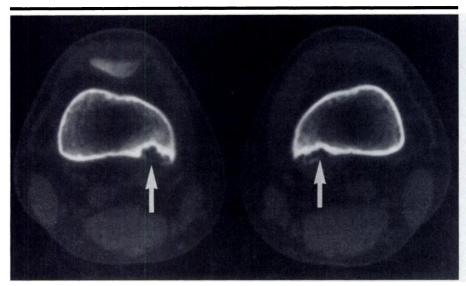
Cortical irregularity syndrome. CT image shows bilateral lesions of the posteromedial distal femora (arrows). The appearance, location, and bilaterality are classic for this disorder.
